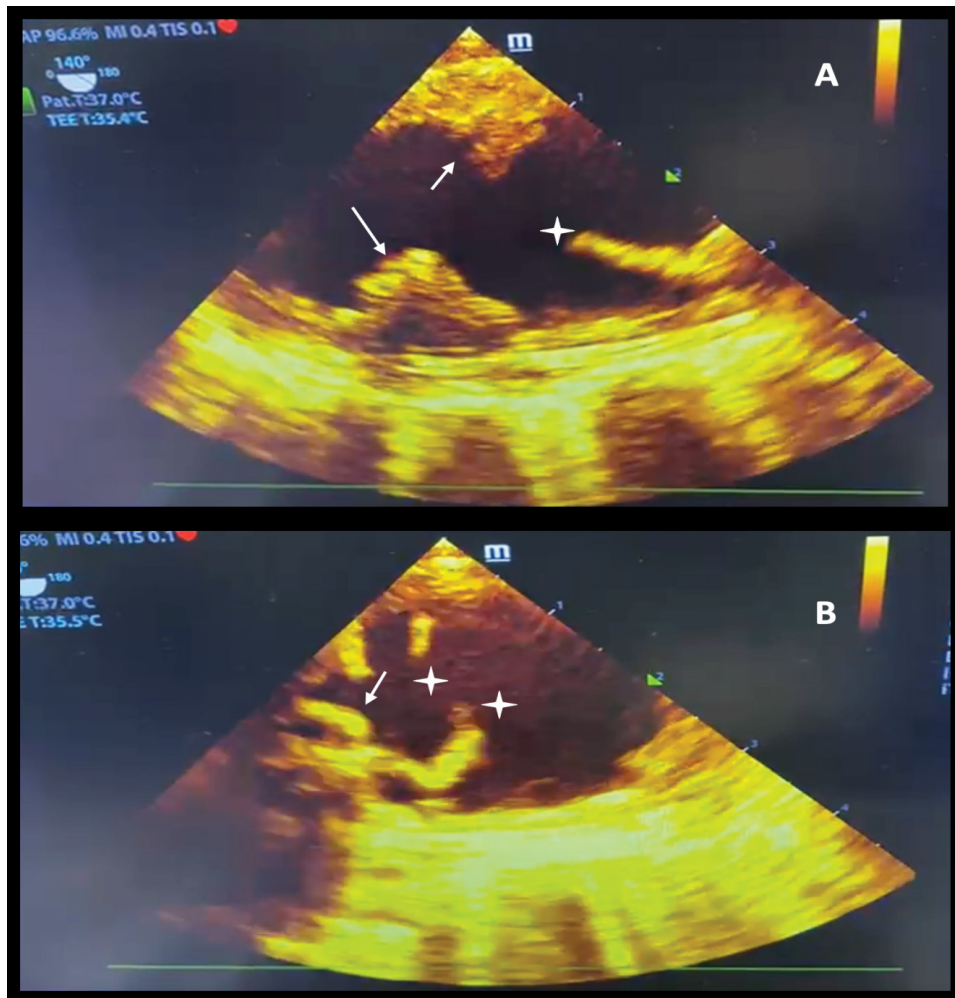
Transesophageal echocardiogram revealing mobile complex atheromatous plaques in the thoracic aorta. (A) Long-axis TEE view and (B) Short-axis TEE view. Thick aortic plaque (Arrow), mobile aortic plaques (White stars).
